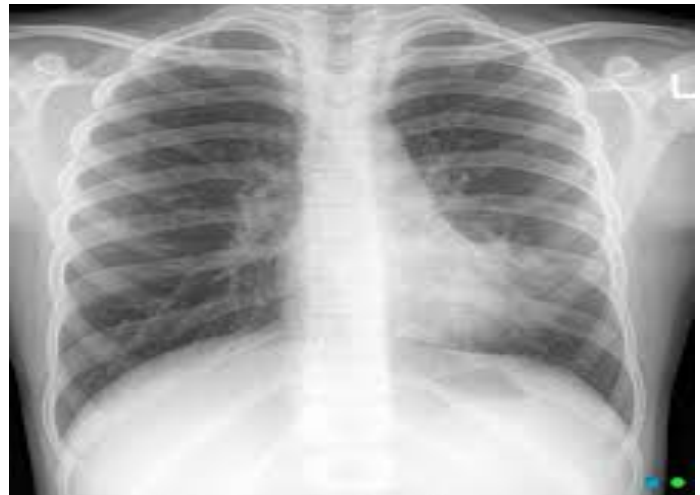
Chest radiograph on day 1 showing infiltrates in left lower zone.
